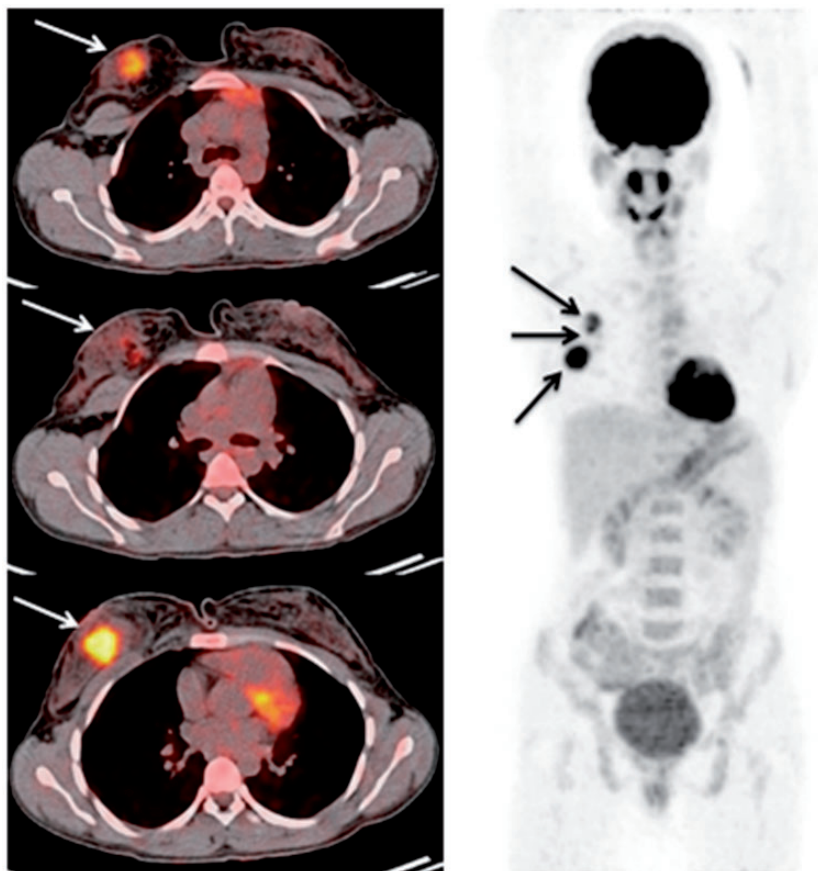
PET/CT images of a patient with early-stage invasive ductal carcinoma of breast. Multifocality was observed (axial fused images on the left side and MIP image on the right side, arrows) and no metastatic lymph node was detected in the axilla in PET/CT. The findings were consistent with the pathology.
